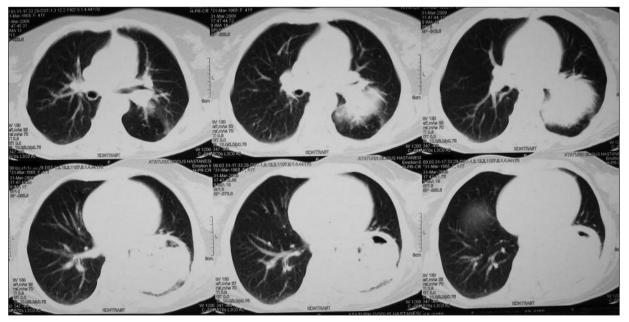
Thorax CT revealing cavitary mass lesion in the left lower lobe.
